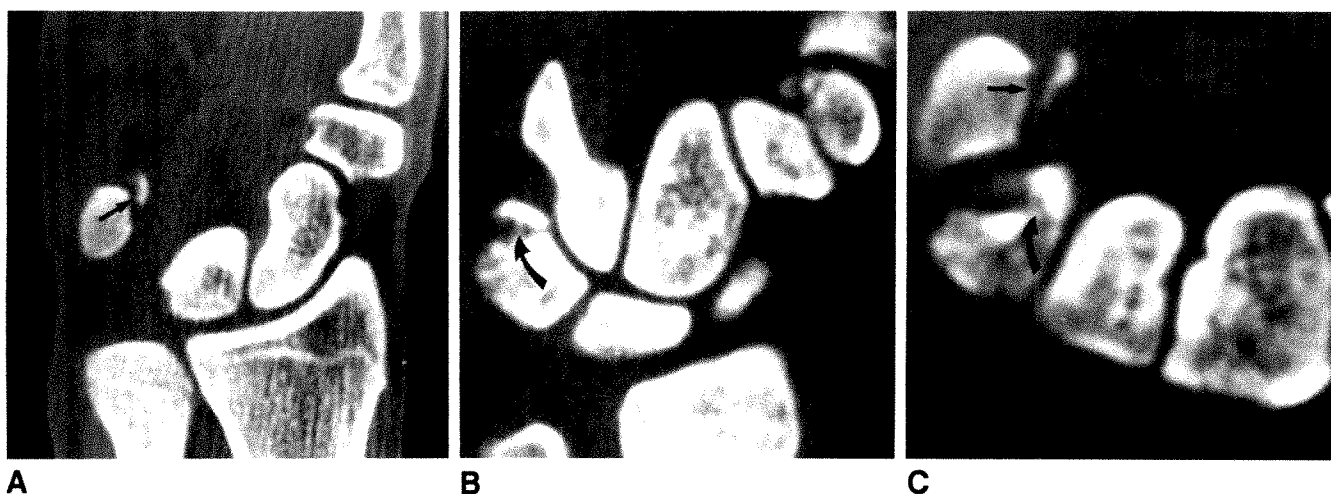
CT may show second fracture in hand or wrist with one radiographically apparent fracture. Oblique radiograph showed fracture of os triquetrum.
